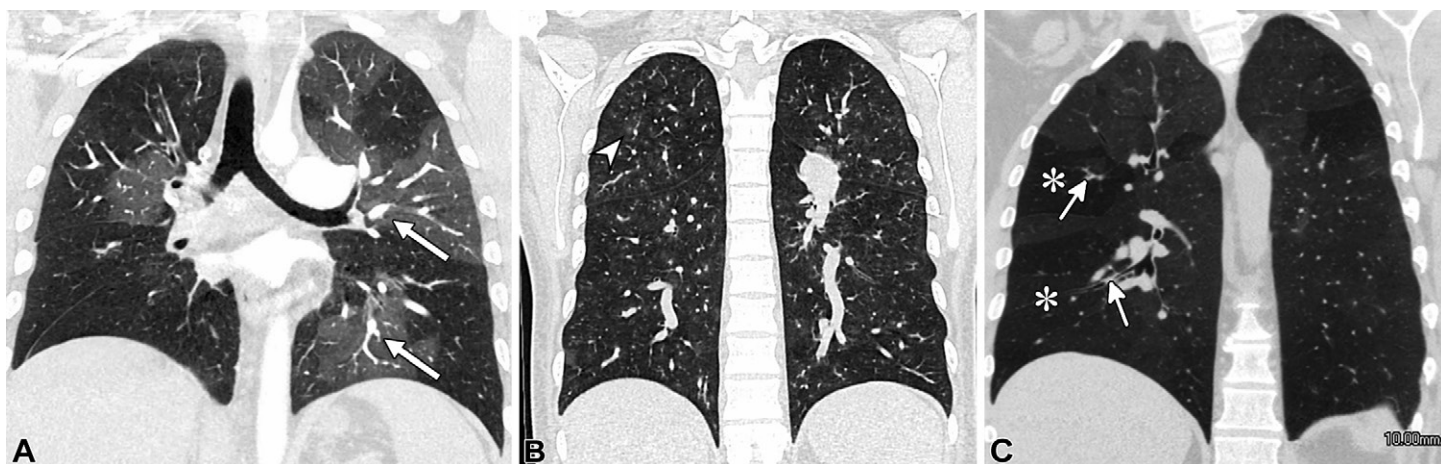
Comparison of patterns of mosaic attenuation in CTEPH, pulmonary arterial hypertension (PAH), and SAD on coronal CT images. (A) In CTEPH, well-defined geographic regions of hypoattenuation correspond to proximally obstructed pulmonary artery branches. The geographic mosaicism may be enhanced by juxtaposition of hyperperfused regions of lung containing engorged pulmonary arteries (arrows) next to lucent lung with decreased size of vasculature due to proximal obstruction. (B) By contrast, the boundaries of mosaic attenuation in PAH are less well defined, and upstream vascular occlusion is absent. Peri-arteriolar ground-glass opacities (arrowhead) are common and have been attributed to various entities, including cholesterol granulomas, periarteriolar hemorrhage, and plexiform arteriopathy. (C) In SAD, there is often accompanying evidence of large airways disease, such as bronchial wall thickening, bronchiectasis, and/or endobronchial mucus plugging (arrows). Areas of hyperlucent lung (*) are related to hypoxic vasoconstriction.
